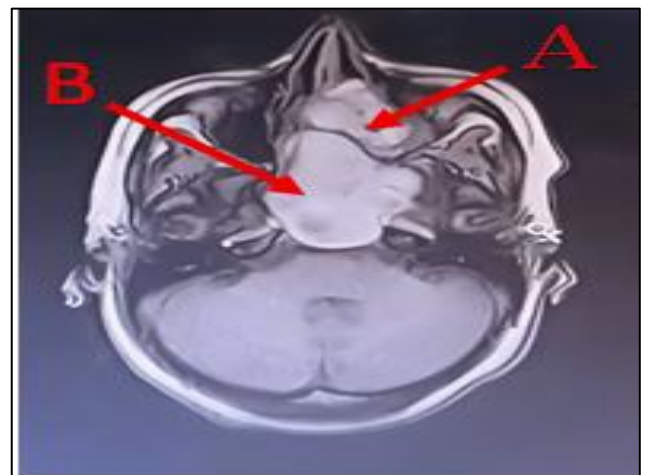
Axial MRI of sinonasal aspergillosis. (A) Obliteration of left optic canal (arrow). (B) Invasion of bilateral cavernous sinuses (arrow).
